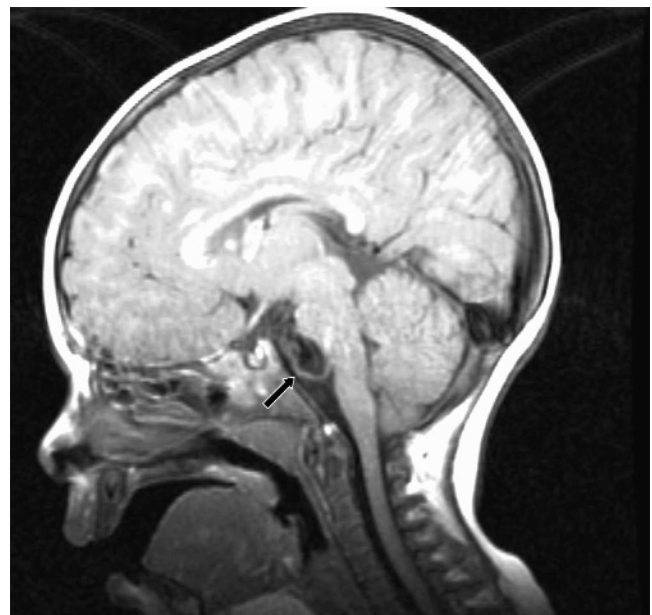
Giant midbasilar artery aneurysm (*arrow*) in an 18-month-old child with tuberous sclerosis complex. The lesion was not present on a magnetic resonance image at 11 months of age.
